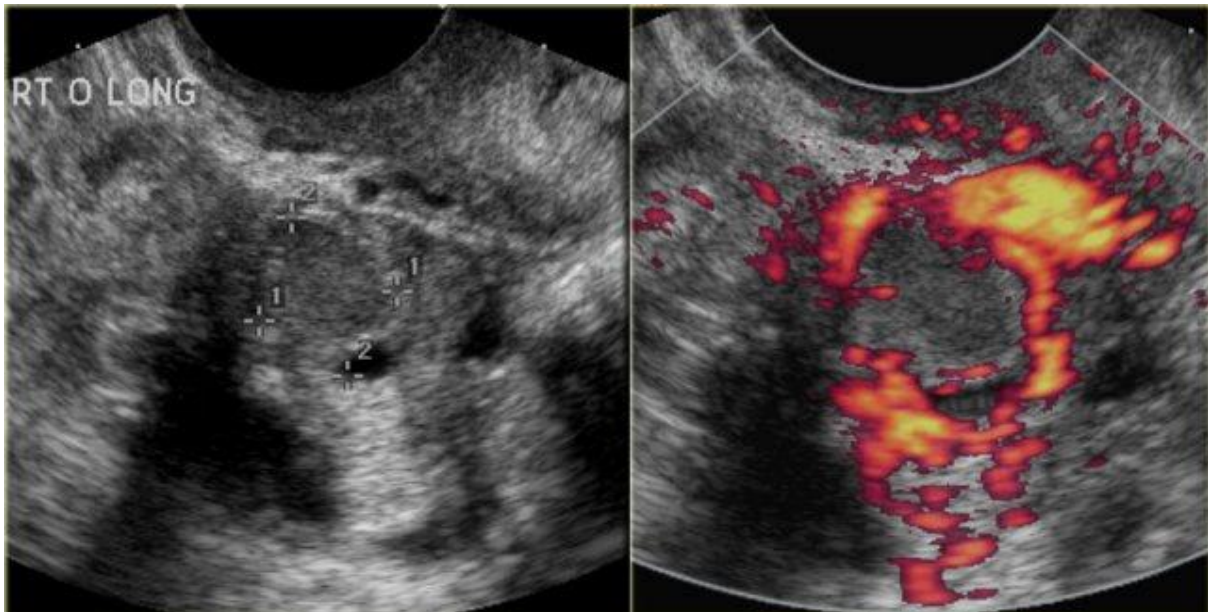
Transvaginal grayscale and color Doppler ultrasound images of the ovary demonstrating increased stromal vascularity and perifollicular blood flow, findings commonly associated with polycystic ovary syndrome (PCOS).
